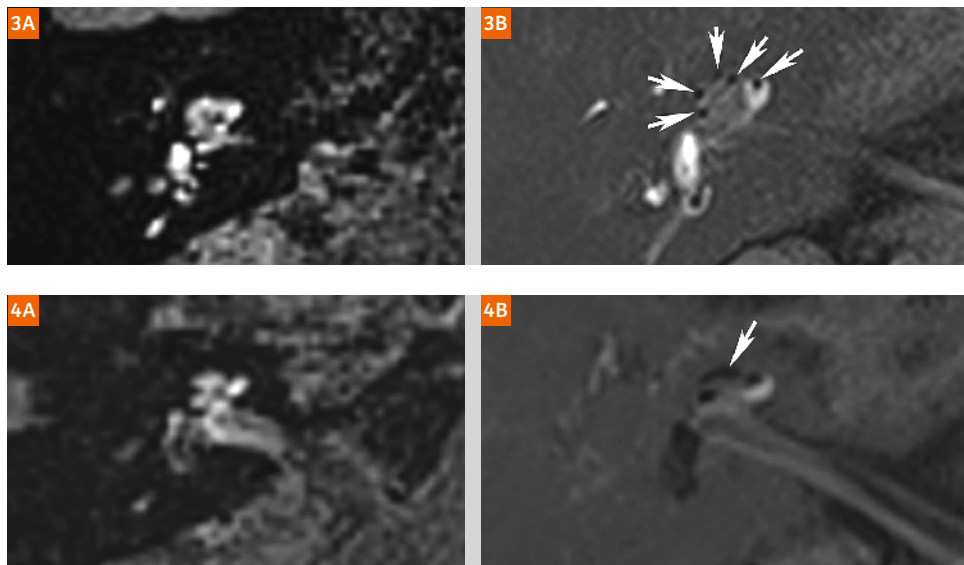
A patient with Ménière's disease of the right ear. The endolymphatic hydrops were not detected on the 3D SPACE FLAIR image (3A) while they were clearly visible at each turn of the cochlea in the 3D real IR image (3B; arrows).
